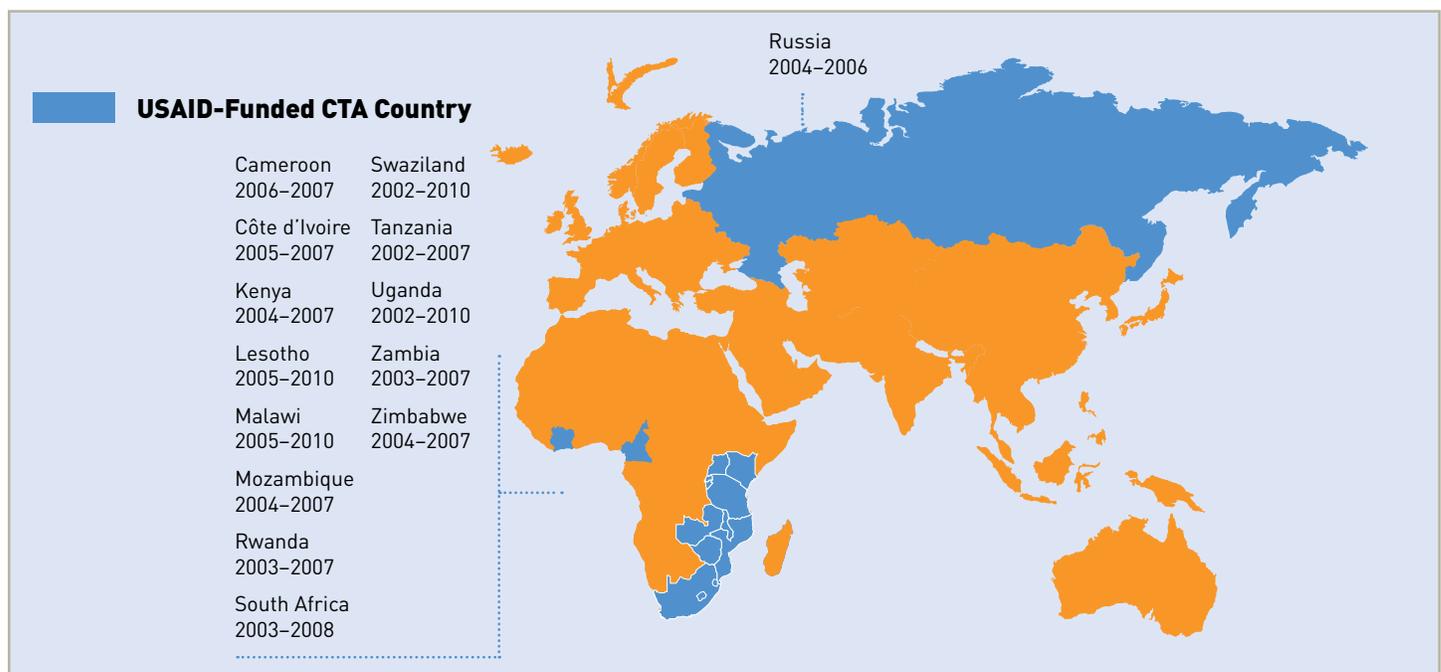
Countries supported with USAID CTA funding, 2002–2010
